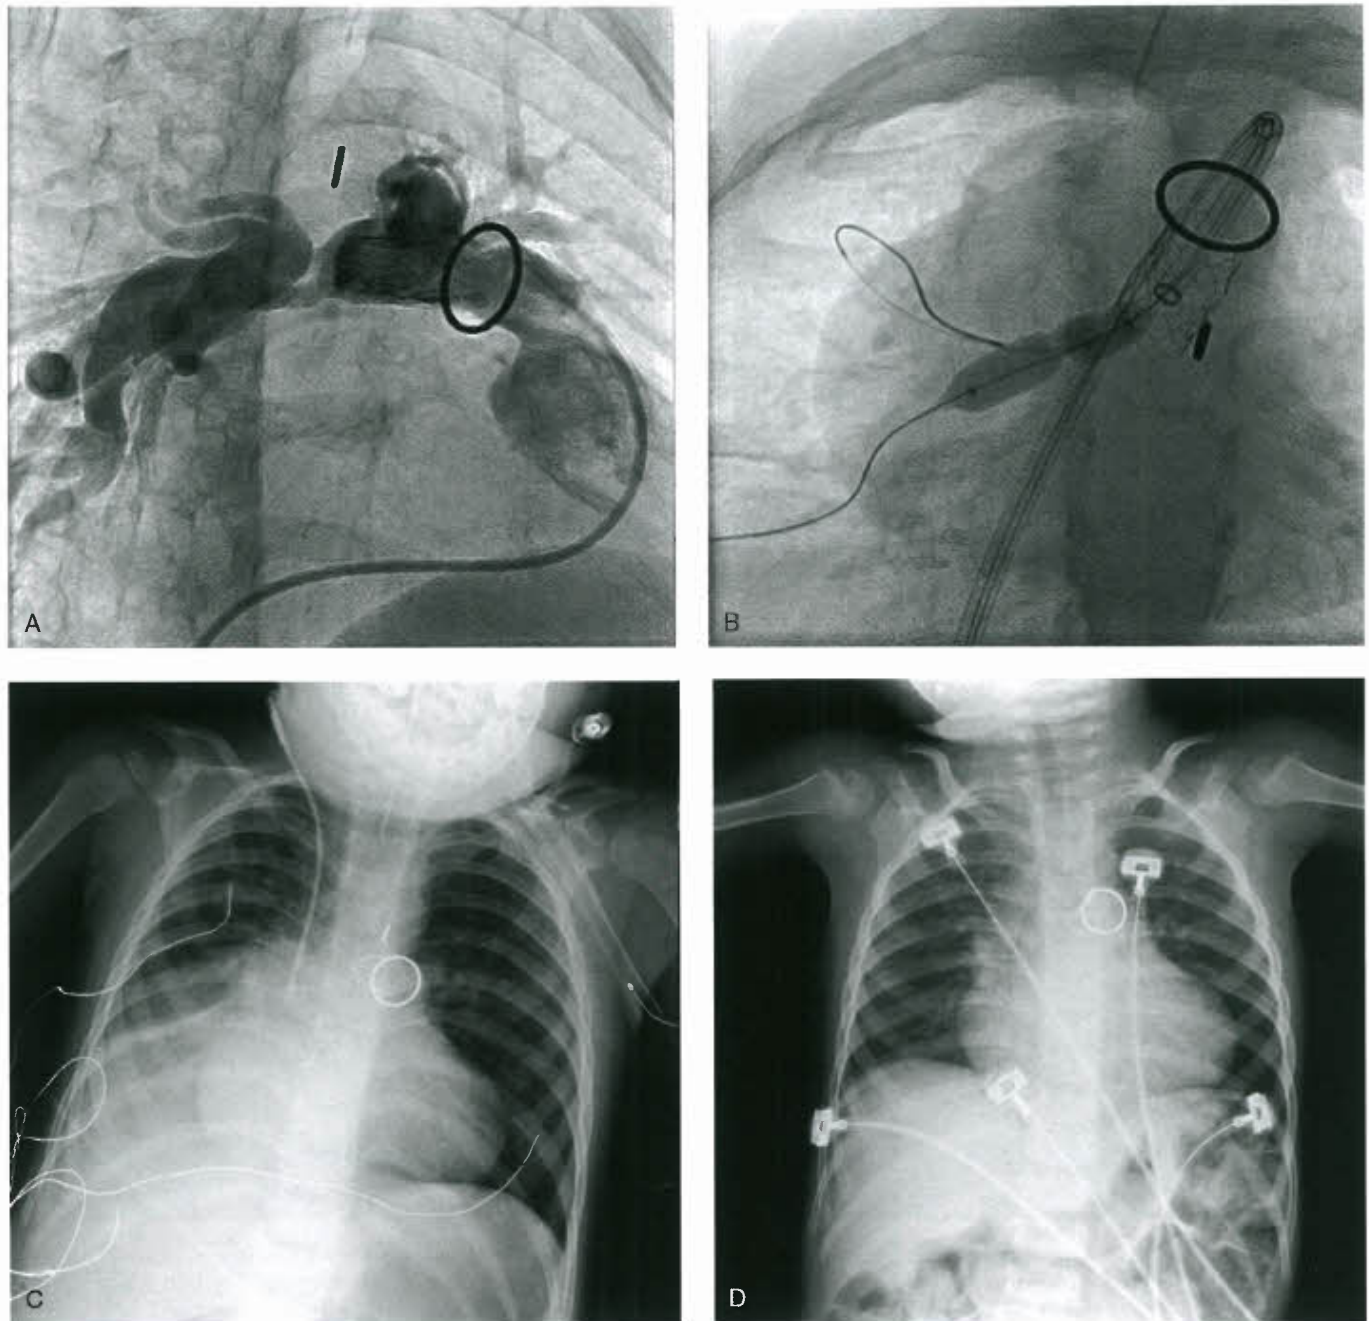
Reperfusion injury after PA rehab. A 2-year-old boy with TOF-PA-MAPCAs and DiGeorge syndrome who underwent a surgical shunt at 2.5 months of age and unifocalization with RVPA conduit at 1 year of age. A: MPA angiography showing significant distal RPA stenoses. B: Serial balloon dilation of distal RPA and lobar branches. C: Chest X-ray demonstrating associated reperfusion injury primarily to the right lower lobe (RLL). D: Follow-up chest x-ray demonstrating the radiographic appearance of this segment having returned to baseline.
